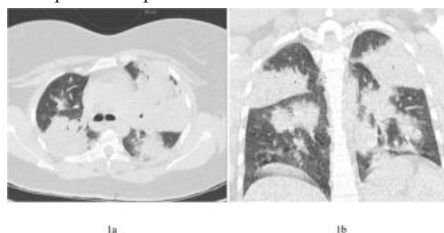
Initial non-contrast CT (NCCT) thorax suggestive of multifocal lobar consolidation secondary to Influenza A community acquired pneumonia with ARDS. 1a. Axial view 1b. Coronal view
